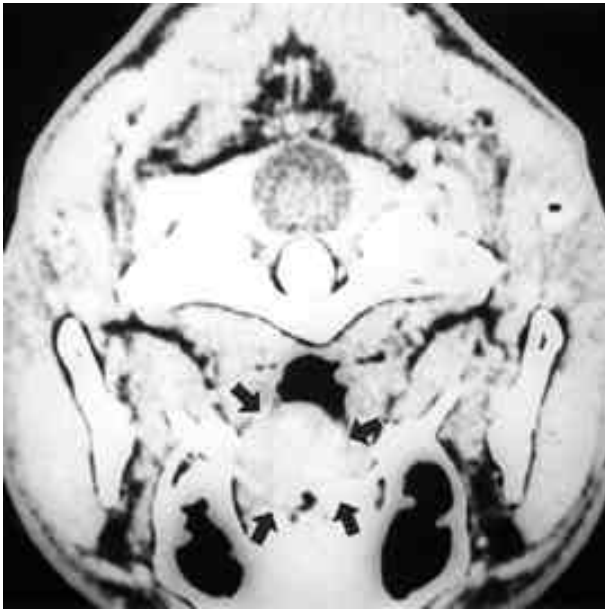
Head and neck CT scan revealed about 2cm sized, round, soft tissue mass in the palate(arrow)
